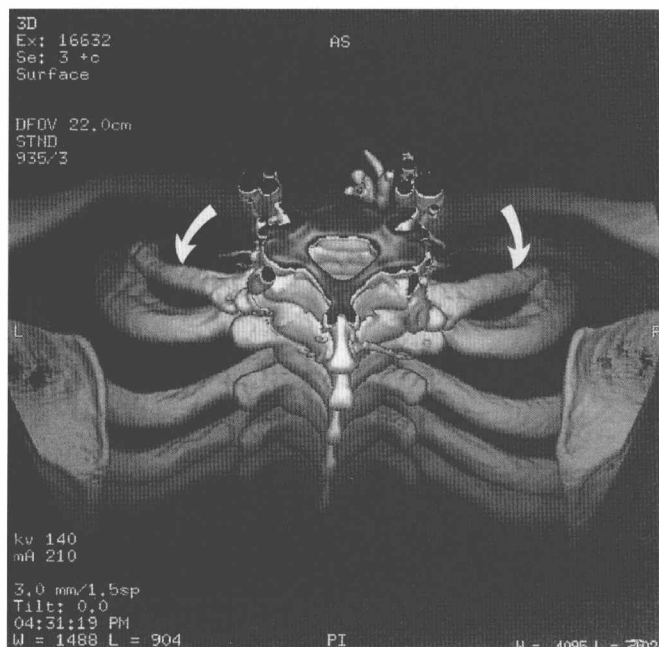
Three-dimensional CT reconstruction of bilateral cervical ribs (arrows).
